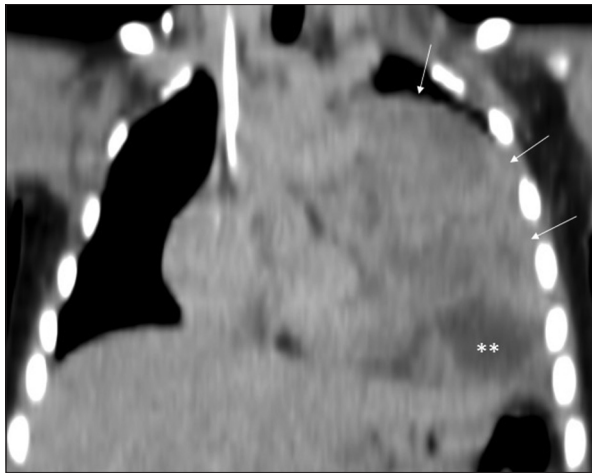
Follow-up coronal computed tomography, progression during therapy, large pericardial mass (arrows) with necrosis ()
